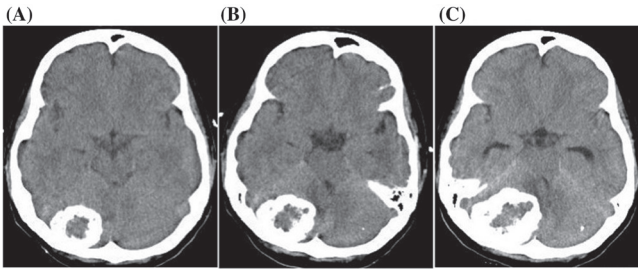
Preoperative computed tomography (CT) scan showing calcified tumor in the right cerebellar hemisphere. A: A calcified tumor in the right cerebellar hemisphere was incidentally discovered 2 years before surgery. B: Follow-up CT 1 year later revealed slow growth of the tumor. C: The tumor grew progressively, compressing the brainstem. The ambient and quadrigeminal cisterns were not visualized, and the inferior horn of the lateral ventricle was enlarged.
